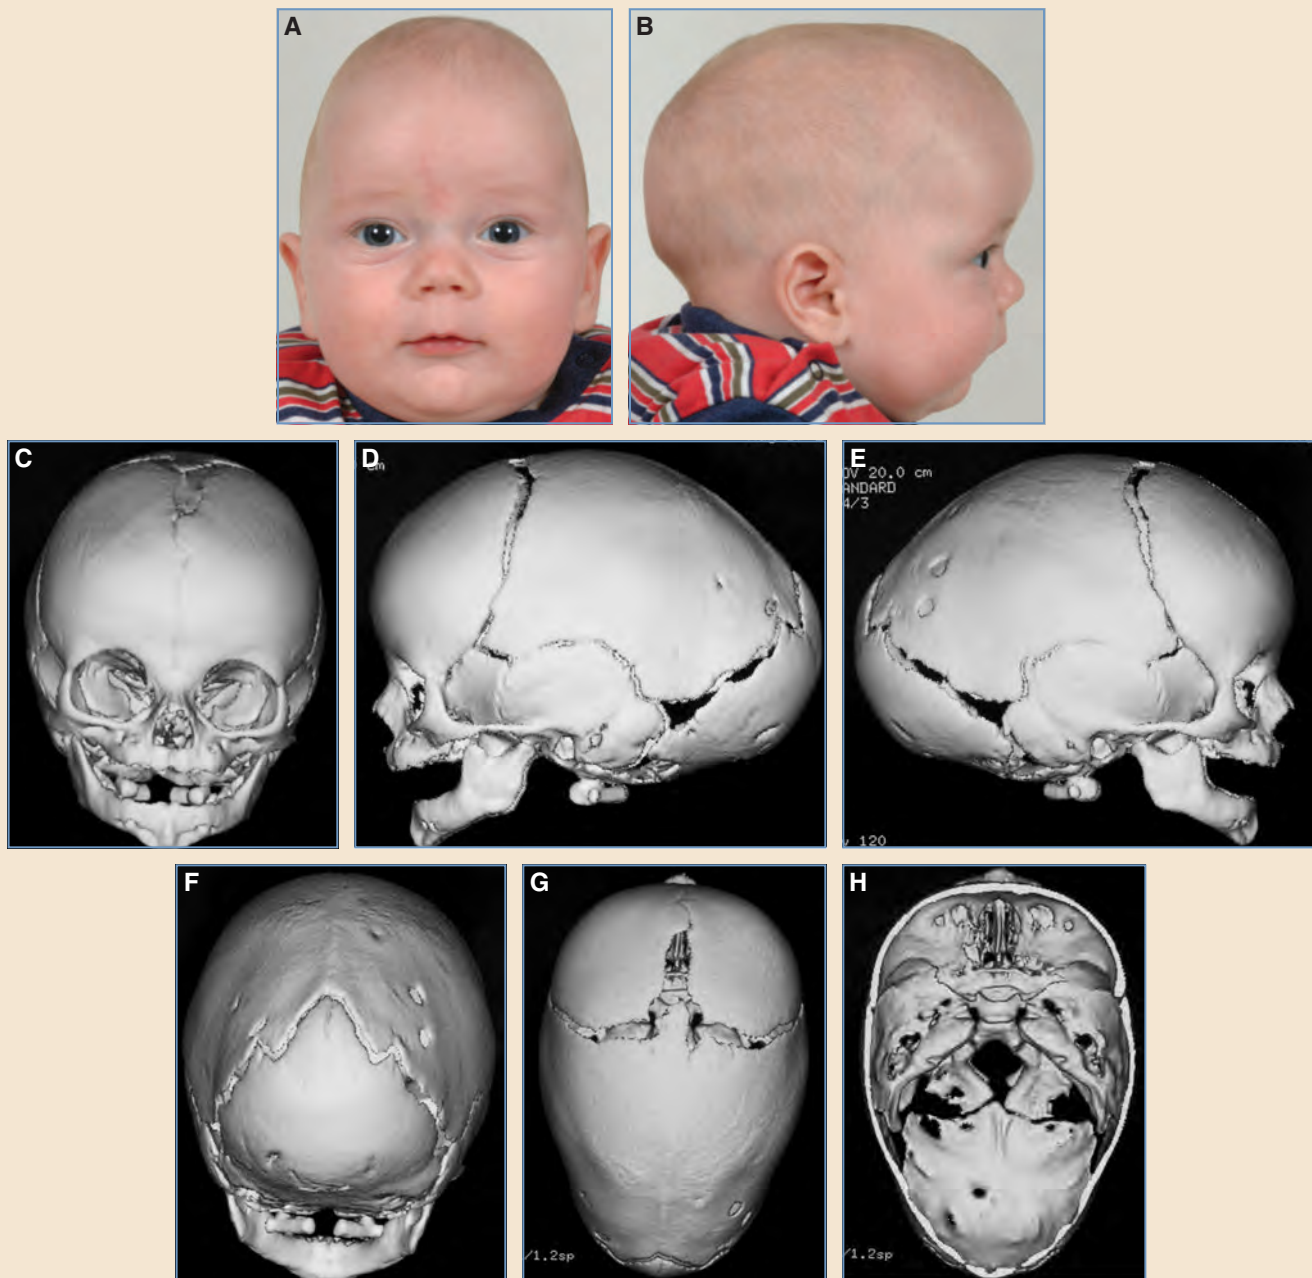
A and B, This 5-month-old boy had scaphocephaly as a result of sagittal synostosis. He underwent an extended strip craniectomy. C-H, Preoperative CT images.
